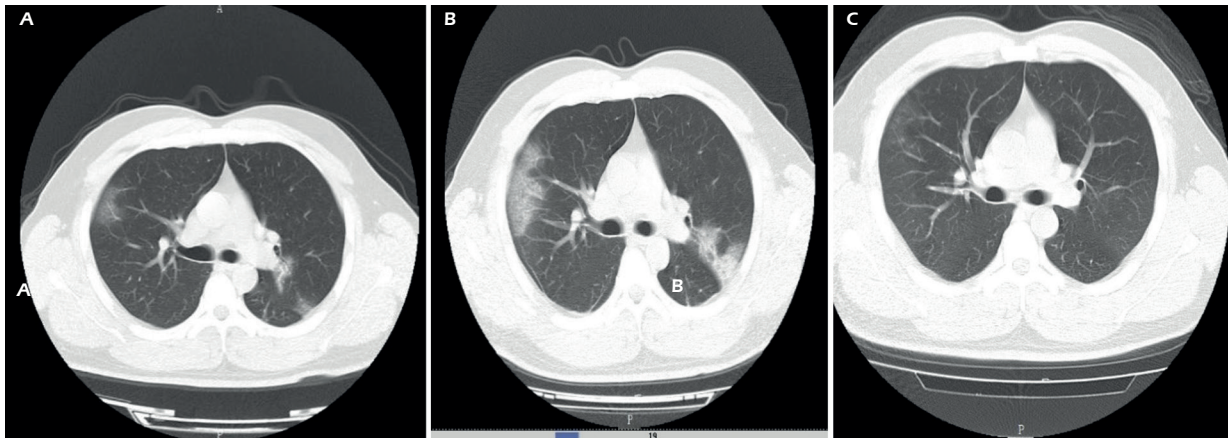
CT morphology distribution of the last CT scan of 84 patients before discharge.
